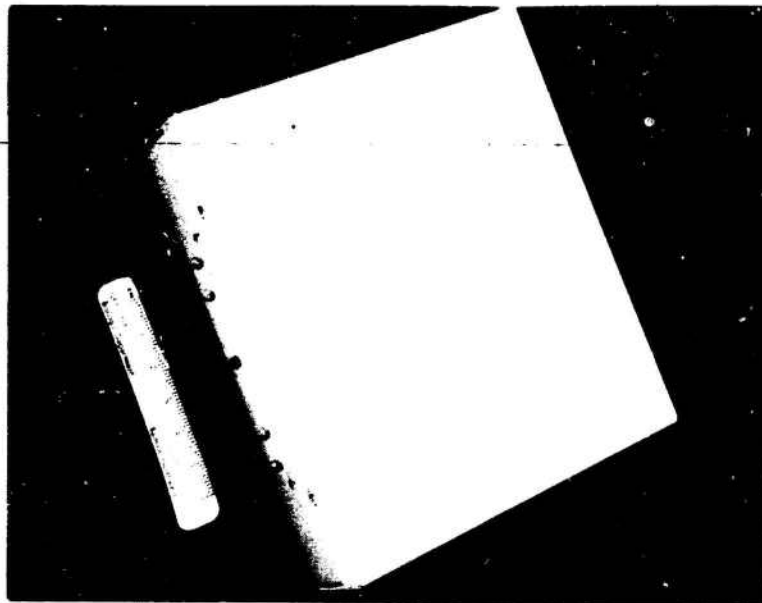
Doppler flowmeter telemetry unit, Parks Electronics Laboratory type (purchased 1967). Case holds batteries.
